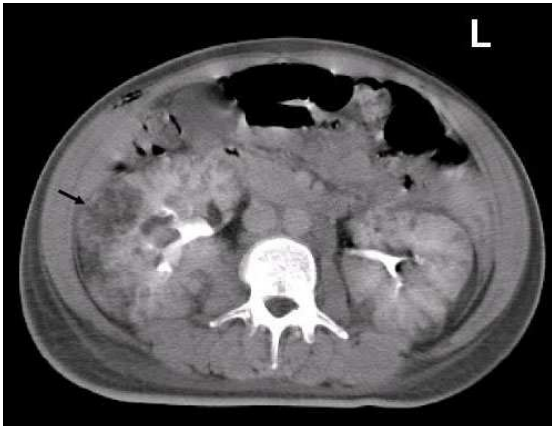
Abdominal CT showed bilateral multiple renal angiomyolipomas.
